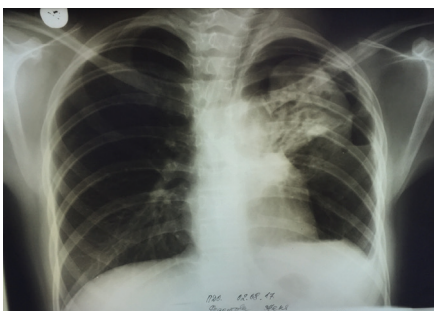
Plain X-ray of the chest organs from 05.09.17.
